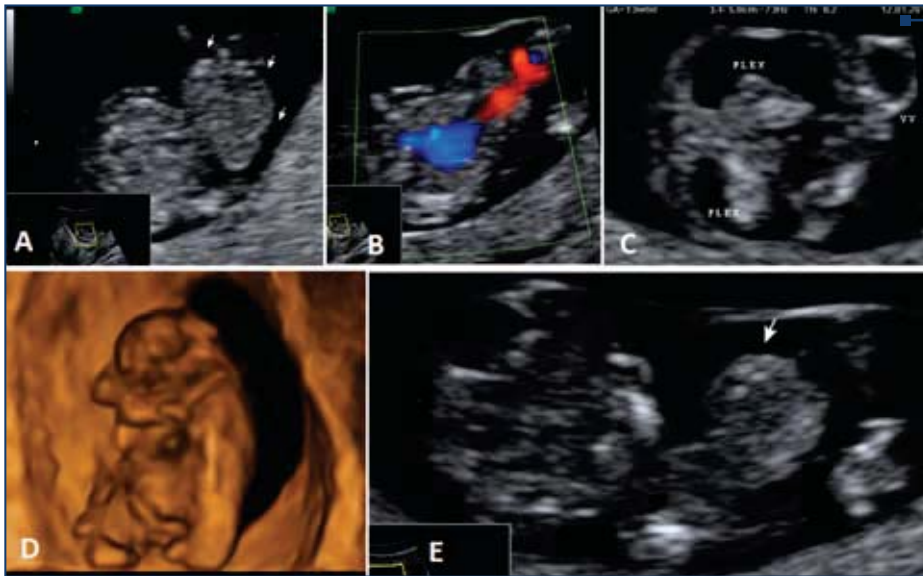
Fetus affected by trisomy 13. A, B: laparoskisis with large exomphalos in gray scale (A) and color Doppler applied (B) to highlight the course of the umbilical vein. C: abnormal cranium and choroid plexus shape and failure in visualizing the normal median septum. D: 3D rendering - surface mode confirming laparoskisis. E: parasagittal view of the affected fetus: abnormal neuronal structures and abdominal defect (arrow).
